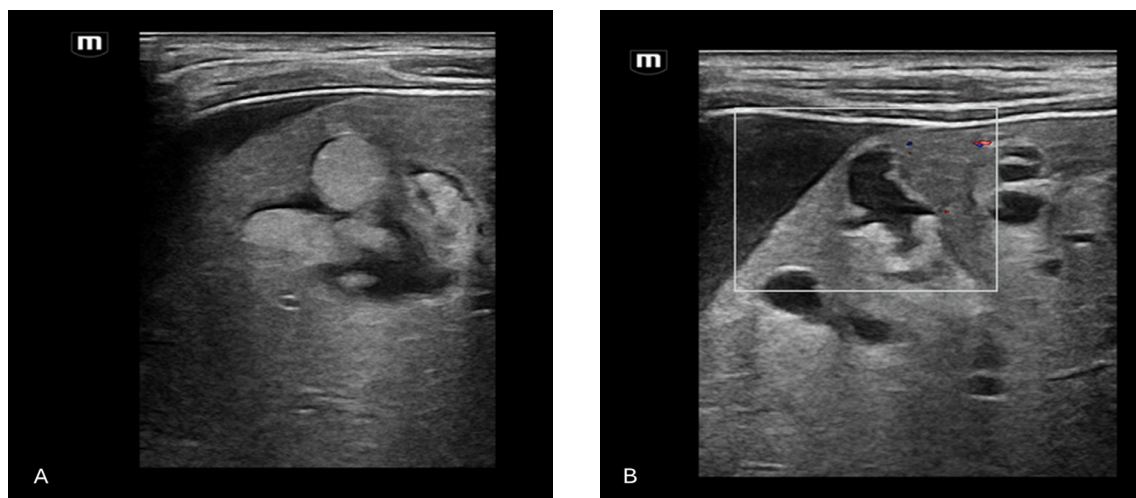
US Images of the Early Cholangiocarcinoma. (A) Gray scale US reveals a hyperechoic intraductal nodule of peripheral intrahepatic duct. (B) Doppler US shows a focal hyperechoic periductal nodule causing focal duct dilatation without vascularity.
